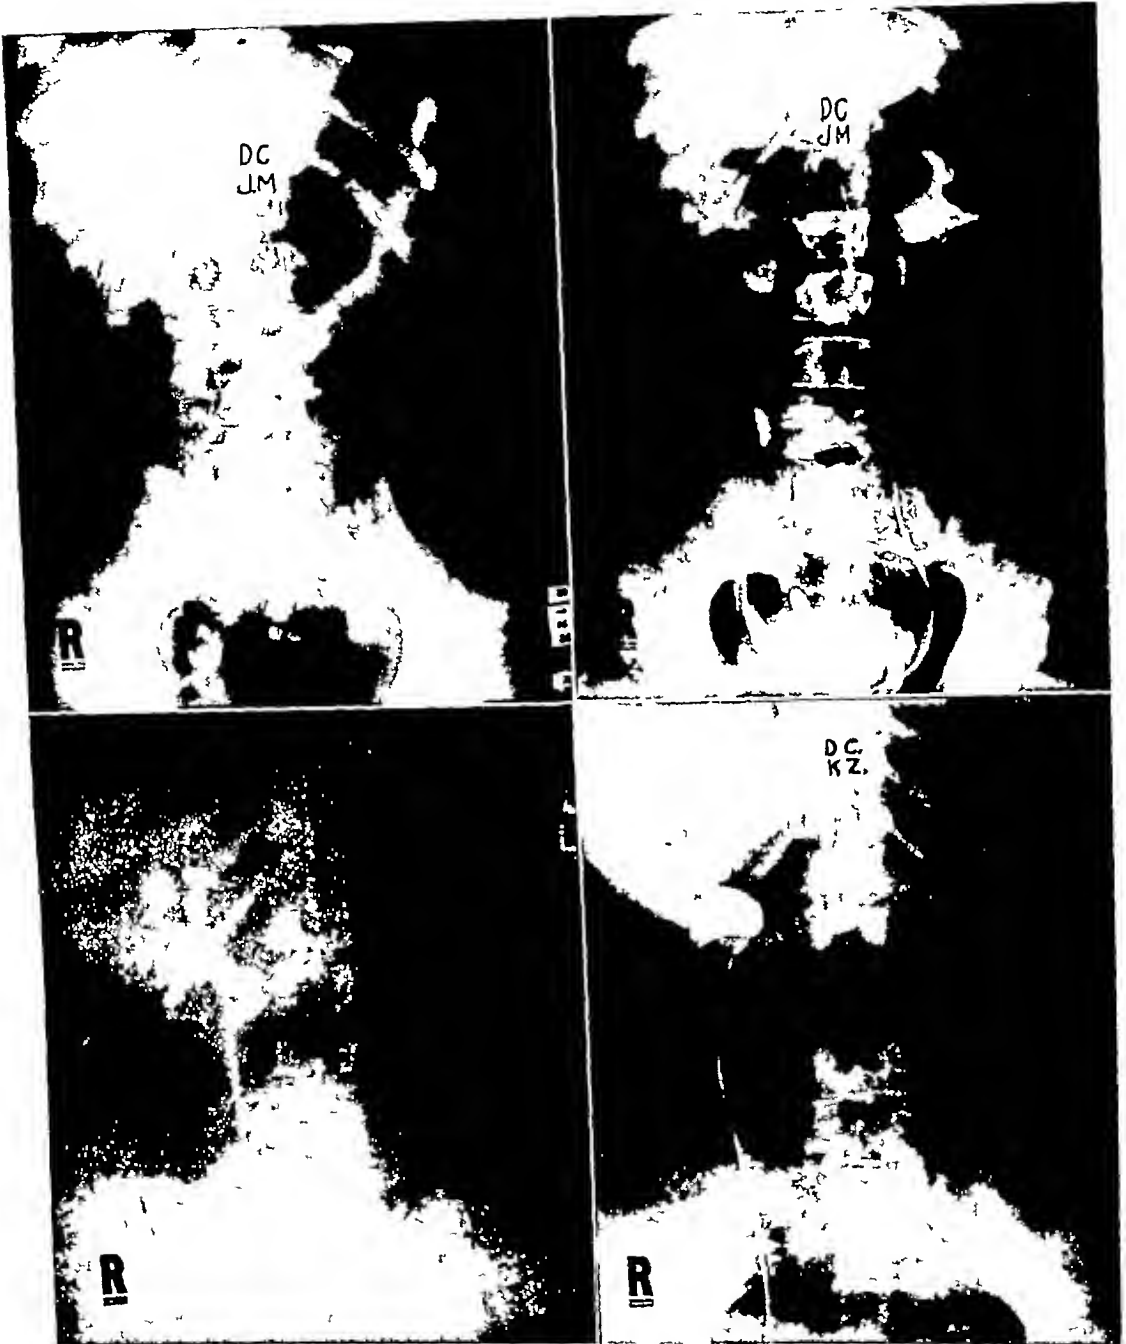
(upper left) Case XVIII Plain roentgenogram showing several irregular areas of calcification in the region of the right kidney following an injury to the kidney one year previously
